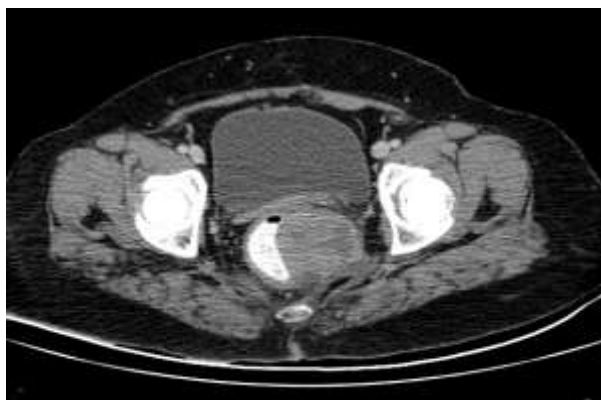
CT-abdomen showed a large hypo dense mass with heterogenous enhancement in the rectum with few enlarged pararectal lymph nodes
